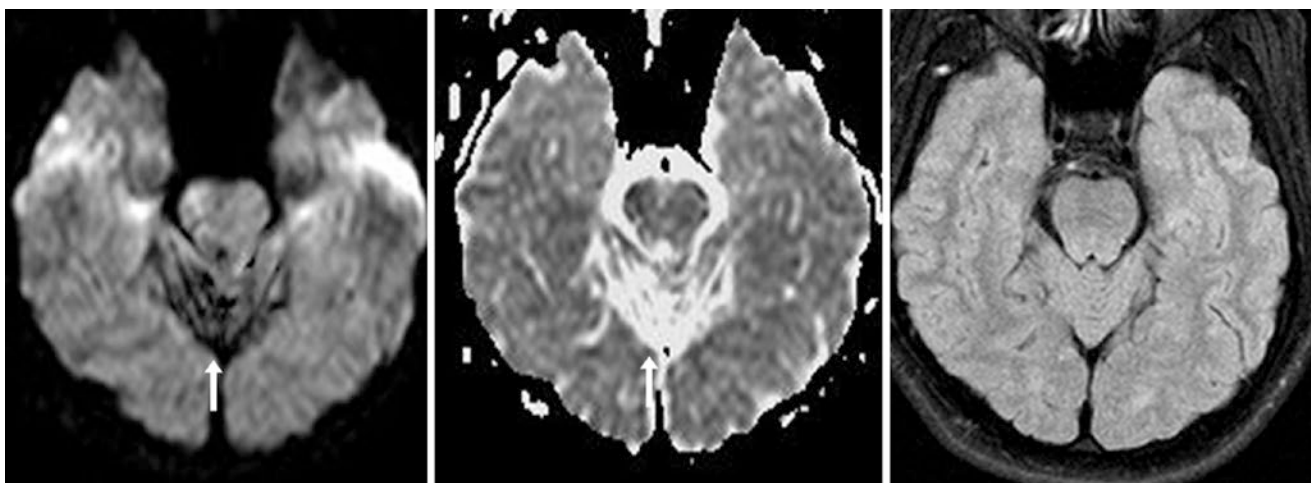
An 80-year-old had a large area of dark artifact overlying the midline superior cerebellum (*arrows*) on DWI MRI at 3 T (*left*). This can be a characteristic location of mechanical vibration artifact, or
